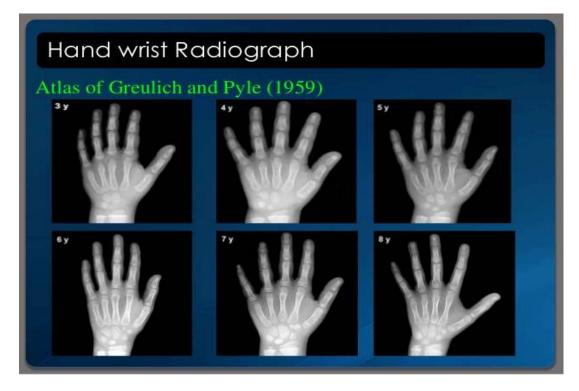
Excerpt from the GP chart, showing left wrist radiographs at various stages of development.
